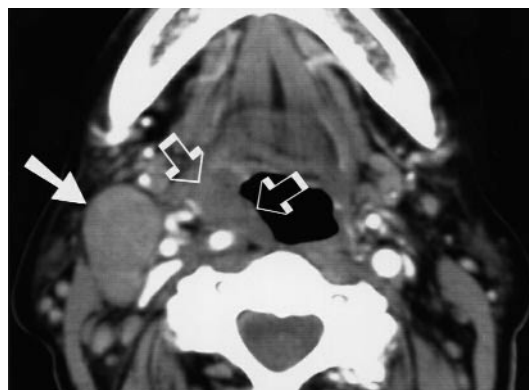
Axial computed tomography (CT) scan showing a biopsy proven B-cell non-Hodgkin's lymphoma of the tonsil (hollow arrows) with adjacent nodal involvement (solid arrow) in a 70-year-old female patient.
